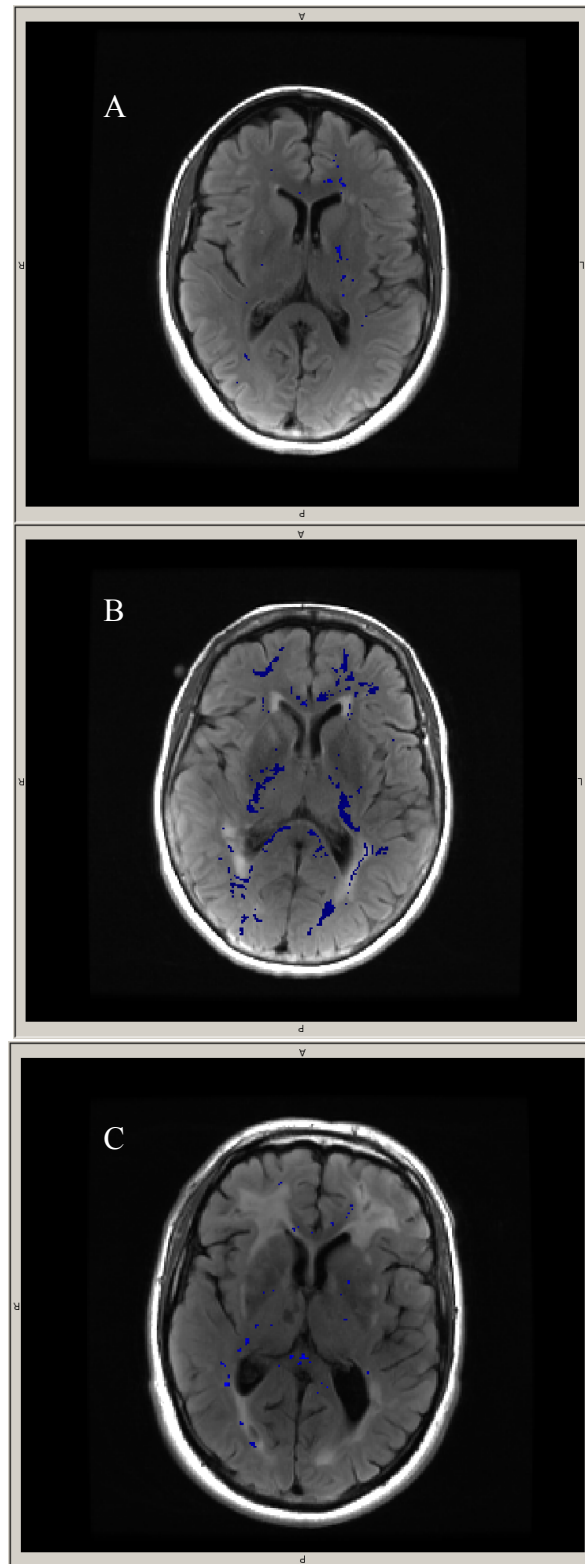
Example images of BBB permeability hotspots (blue) overlaid onto T2 FLAIR scans. A) Control. B) Sporadic SVD. C) CADASIL.
